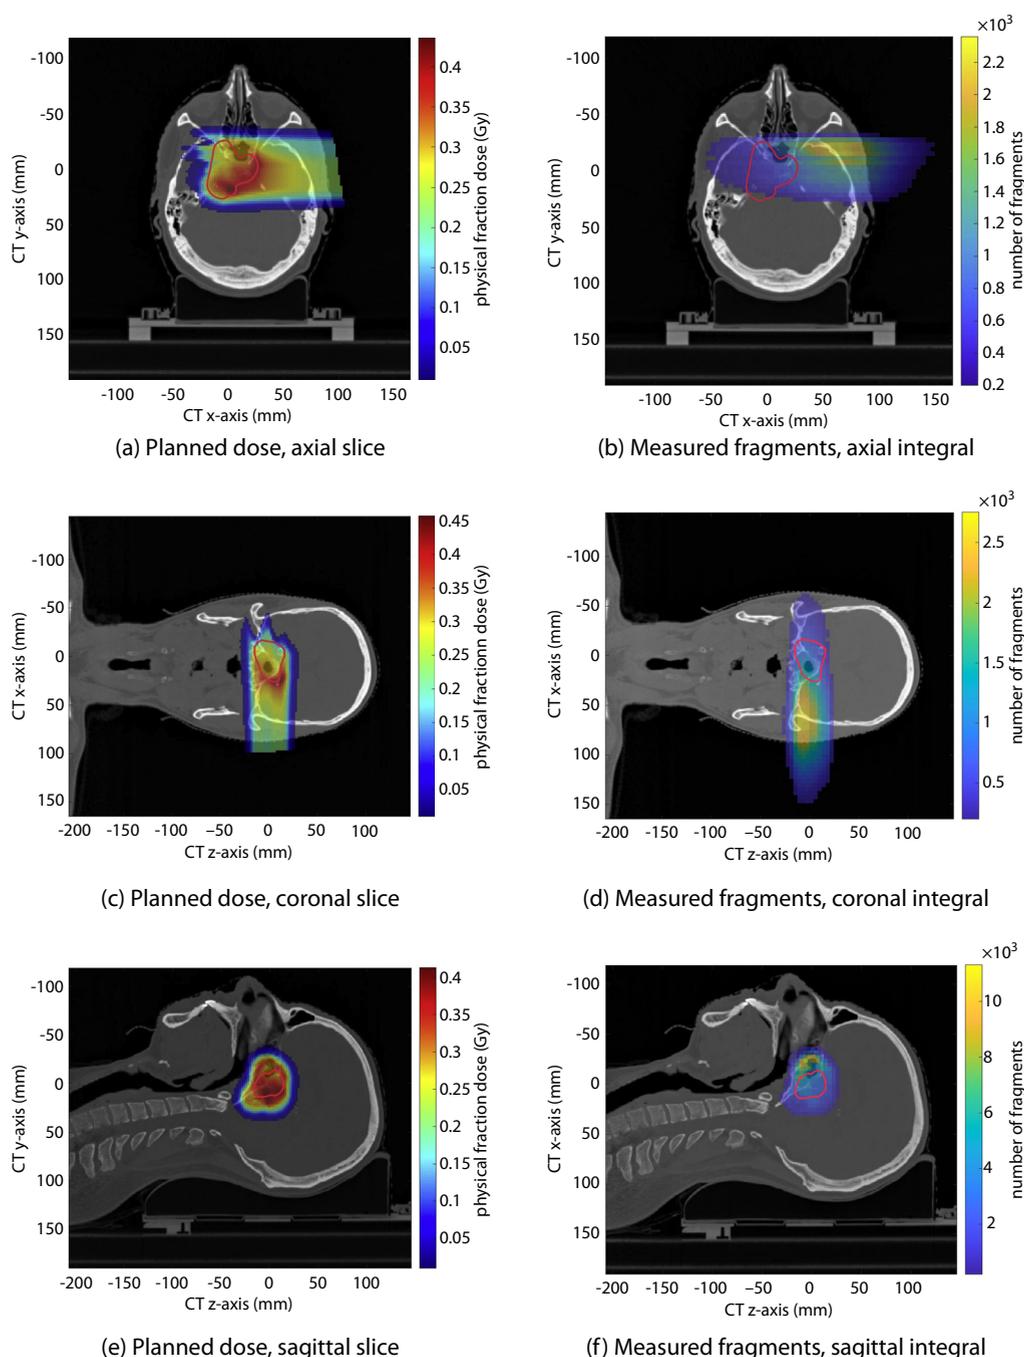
(a, c, e) Slices of the planned physical dose distribution. (b, d, f) Integral fragment distributions measured with the monitoring system (treatment fraction 18). The red line delineates the planning target volume. *Abbreviation:* CT = computed tomography.
